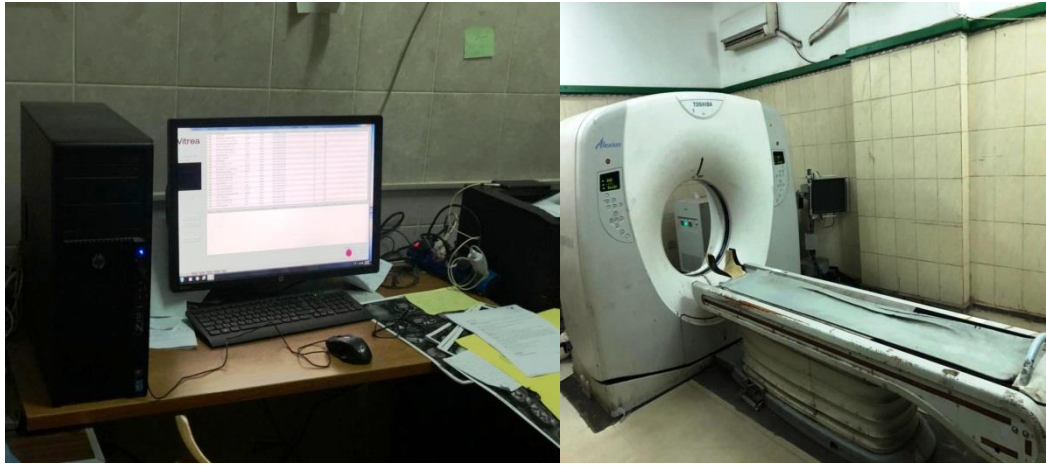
Work station & CT scanner in Radiology department in Sohag University Hospital
